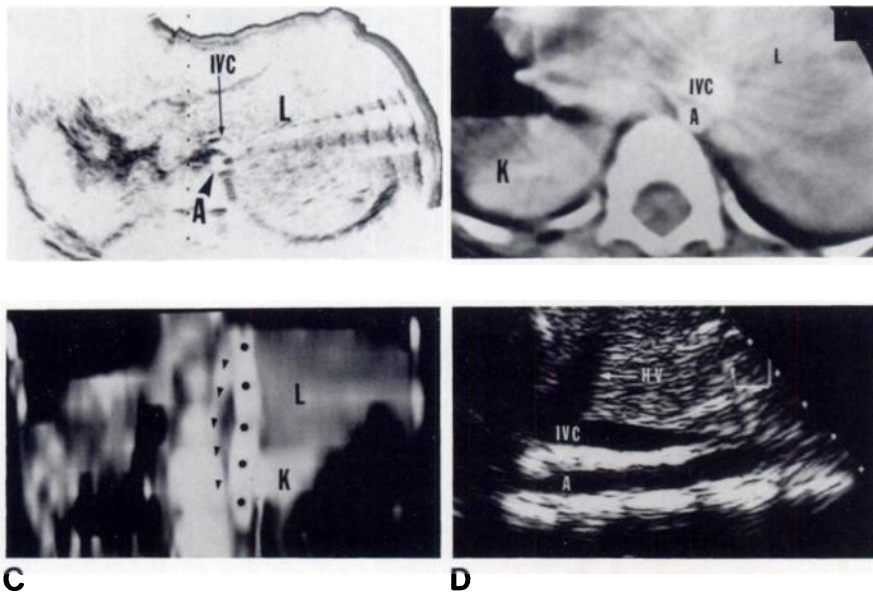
Right isomerism (asplenia syndrome), case 8, 4-year-old girl. A, Transverse sonogram 0.5 cm below xiphoid. Crossing of inferior vena cava (IVC, arrow) and aorta (A, arrowhead) to left of spine. In all cases of asplenia syndrome, aorta and inferior vena cava cross midline or are located on same side of spine. Vascular anatomy easily demonstrated. Liver (L) on left. B, CT scan at comparable level. Inferior vena cava (IVC) and aorta (A) with contrast enhancement. Kidney (K) on right with left-sided liver (L). No splenic tissue seen. C, Coronal reconstruction in plane through IVC and aorta. Actual course of inferior vena cava (dots) and aorta (arrowheads). Aorta and inferior vena cava, contrary to normal relationship, are on same side of upper abdomen and often superimpose or cross in frontal projection. Liver (L) and left kidney (K). D, Longitudinal two-dimensional sector scan at 1 cm to left of midline. Hepatic vein (HV) and inferior vena cava (IVC) enter atrial structure with aorta (A) directly below caval segment. Real-time imaging showed vascular pulsations.
